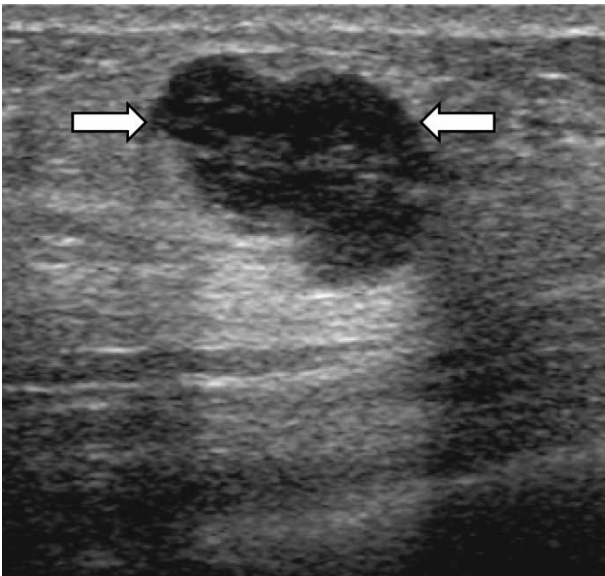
A 42-year-old female with a grade 3 invasive ductal carcinoma. Ultrasound shows an irregular shaped, circumscribed marginated, hypoechoic, parallel orientated mass (arrows) with an abrupt boundary and no internal calcifications. The cancer was ER and PR negative, and HER-2/*neu* negative.
